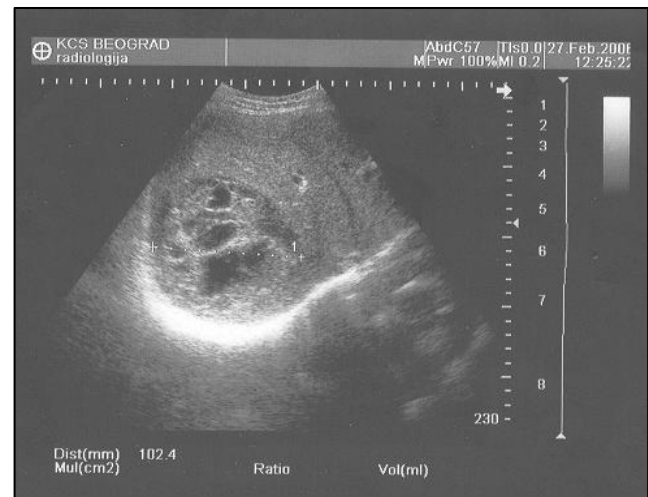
Ultrasonography showed in the projection of the right liver lobe heteroechoic hydatid cyst
